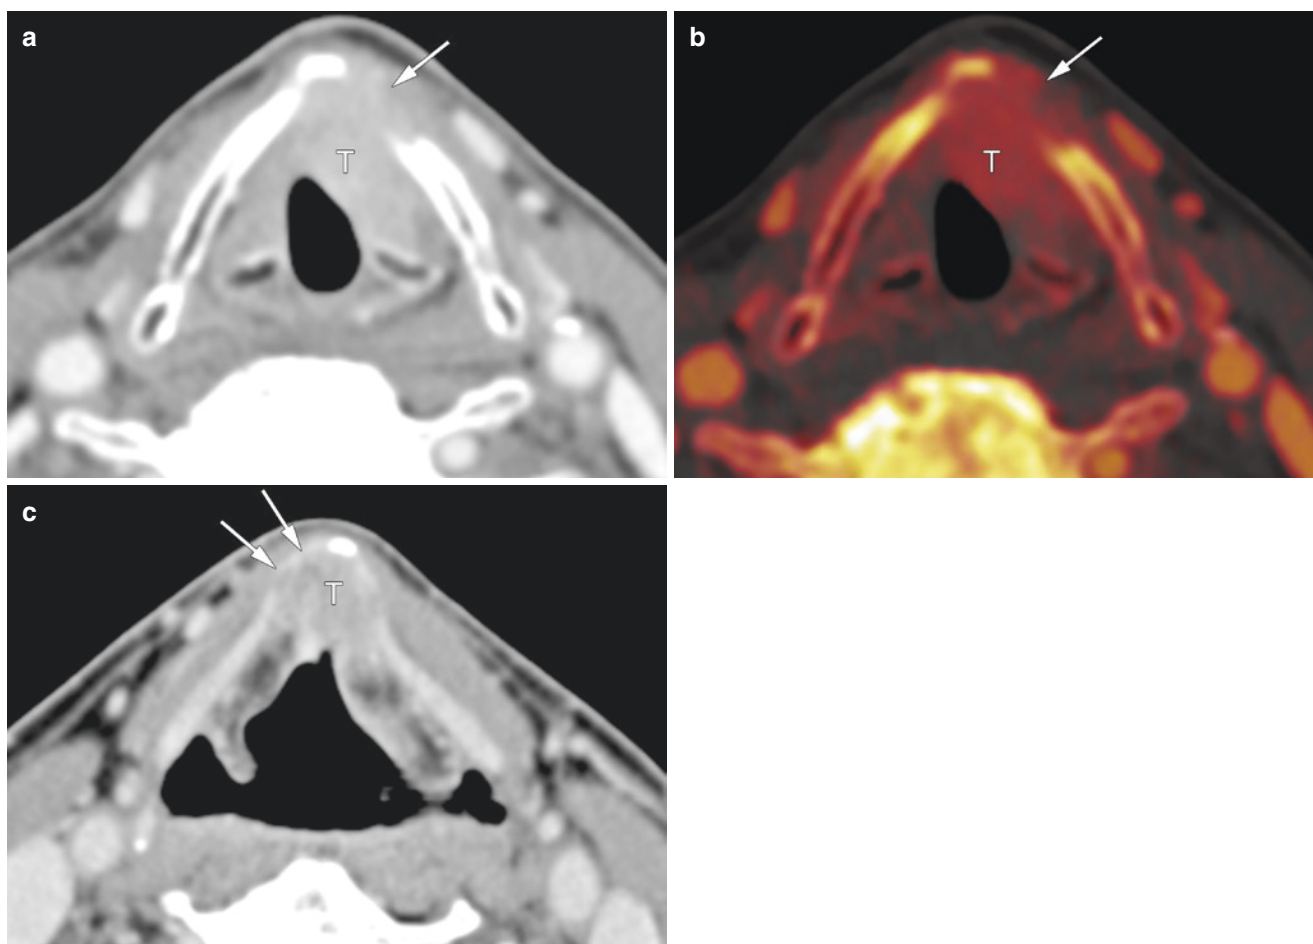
Glottic carcinoma with thyroid cartilage invasion through the outer cortex by dual-energy CT. WA image (a) at the glottic level shows tumor (T) invasion into the thyroid cartilage, spreading into the extralaryngeal soft tissue (arrow). On the IO image (b), the tumor
